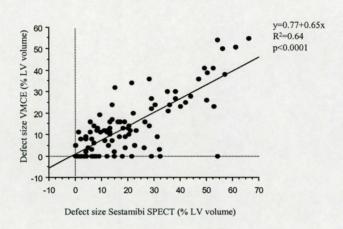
Simple regression analysis of infarct sizes measured by Sestamibi single photon emission computer tomography (SPECT) and venous myocardial contrast echocardiography (VMCE).
